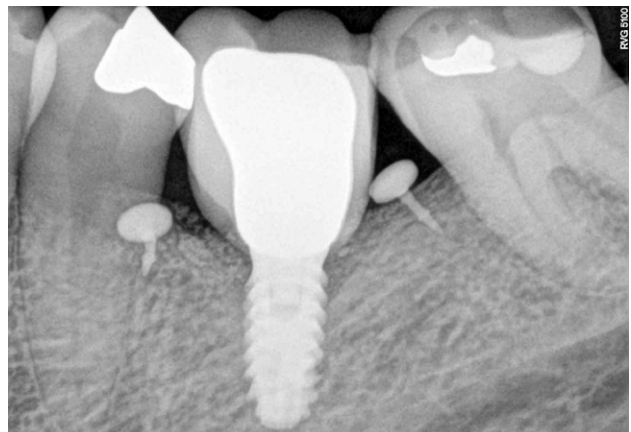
X-ray exam at 6 months of follow-up to case 3.
